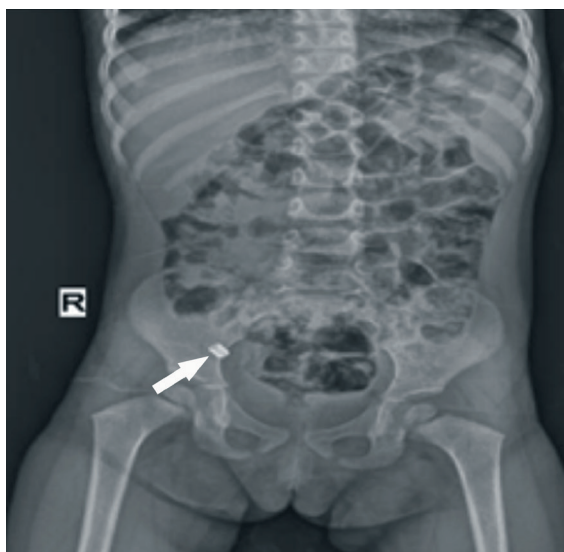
Abdominal X-ray image demonstrates a radiopaque foreign body (arrow) in the right lower quadrant.
